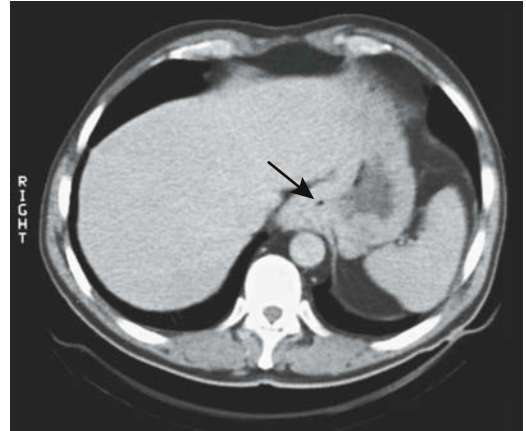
Distal esophageal adenocarcinoma. CT reveals diffuse infiltration of surrounding tissues (arrow).
